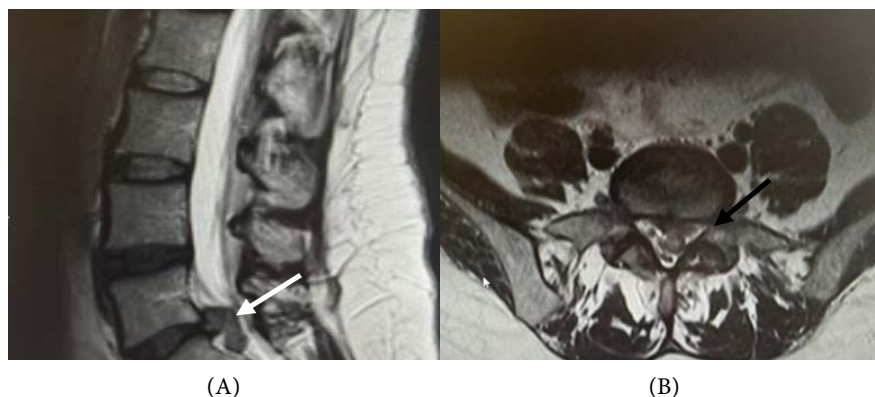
(A) Lumbo-sacral T2W sagittal MRI with extruded and inferiorly migrating disc herniation at L5/S1 level (white arrow). (B) Lumbo-sacral T2W axial MRI, showing extruded and dural Subarachnoid Hemorrhage at L5/S1 level and compression on the left S1 root (black arrow).
